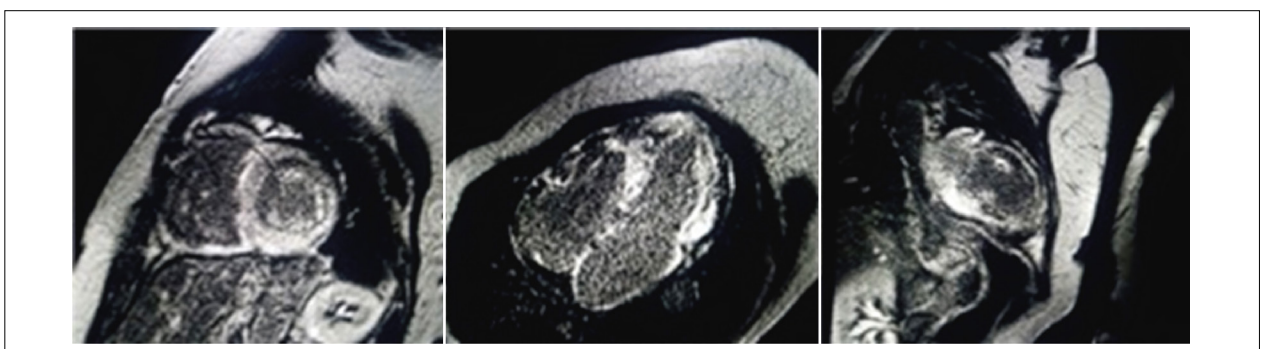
Cardiac magnetic resonance imaging showing mesocardial enhancement in the left ventricle, right atrium and left atrium, typical of amyloid infiltration.
